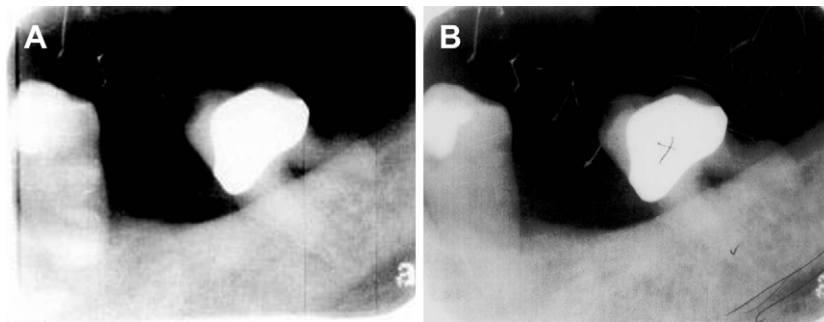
A, Periapical radiograph of the left second mandibular molar shows a large restoration and evidence of involvement of the furcation area, significant resorption of the distal root and bone. Radio-opacity of the crestal bone extends to overshadow the mesial root. B, Enhanced contrast view shows mottled to patchy radiolucency throughout the tooth-bearing area that is accentuated at the distal area.
